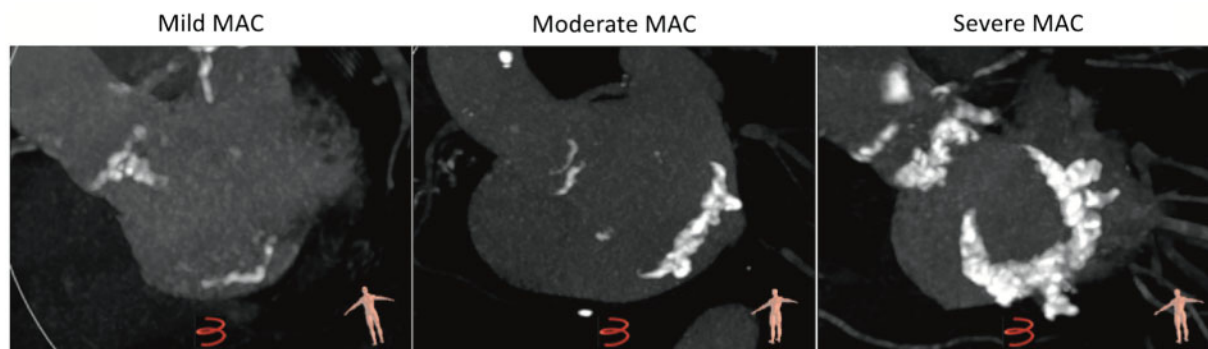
Grading of MAC severity by computed tomography. MAC severity was qualitatively determined by the circumferential involvement of the mitral ring: mild was defined as involvement in less than one-third of the annulus; moderate between one-third and half; and severe if the calcification was present in more than half of the mitral annulus circumference.^{1,15} MAC, mitral annular calcification.
